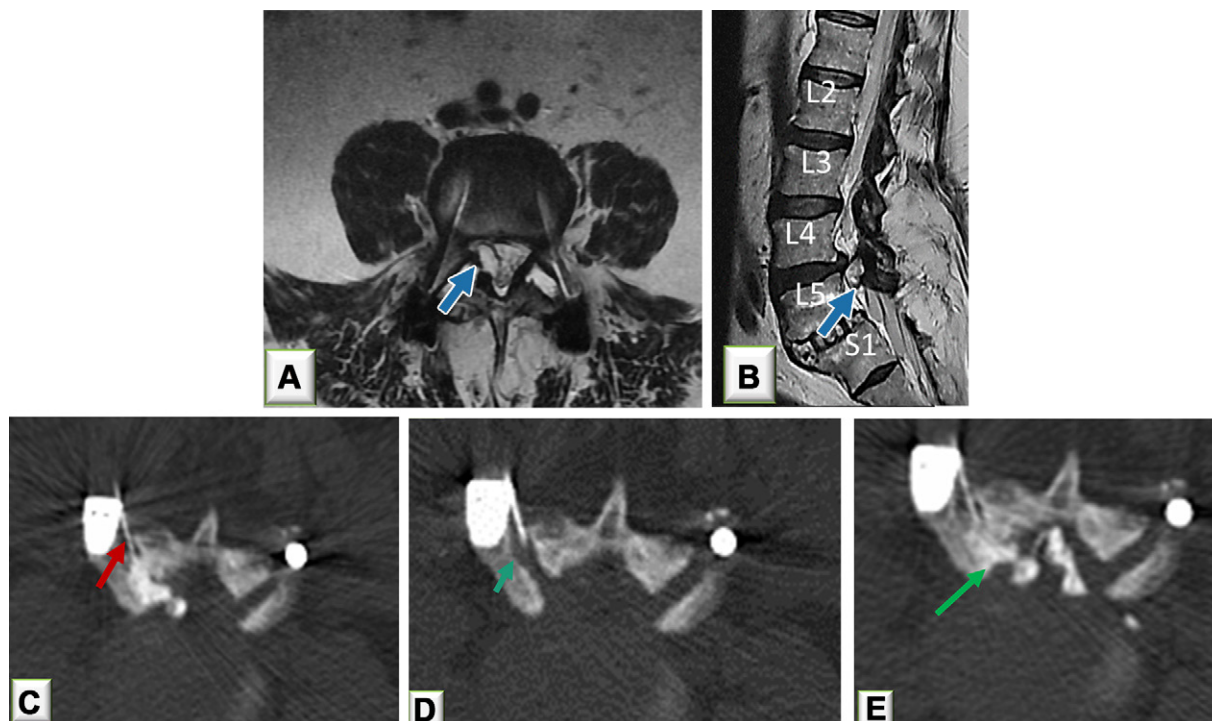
Treatment of lumbar spine synovial cyst. (A, B) Axial (A) and sagittal (B) lumbosacral spine T2-weighted MR images show a right synovial cyst (arrow) with facet joint arthropathy. Note the pedicle screw instrumentation. (C) Axial image of CT-guided indirect rupture of the synovial cyst shows the needle tip (arrow) in the right facet joint capsule. (D) Axial CT image shows contrast agent filling the facet joint and the communicating synovial cyst (arrow). (E) Axial CT image shows that continued pressurization during contrast agent injection results in cyst rupture, which is confirmed by the epidural flow of contrast agent spilled from the cyst (arrow).
